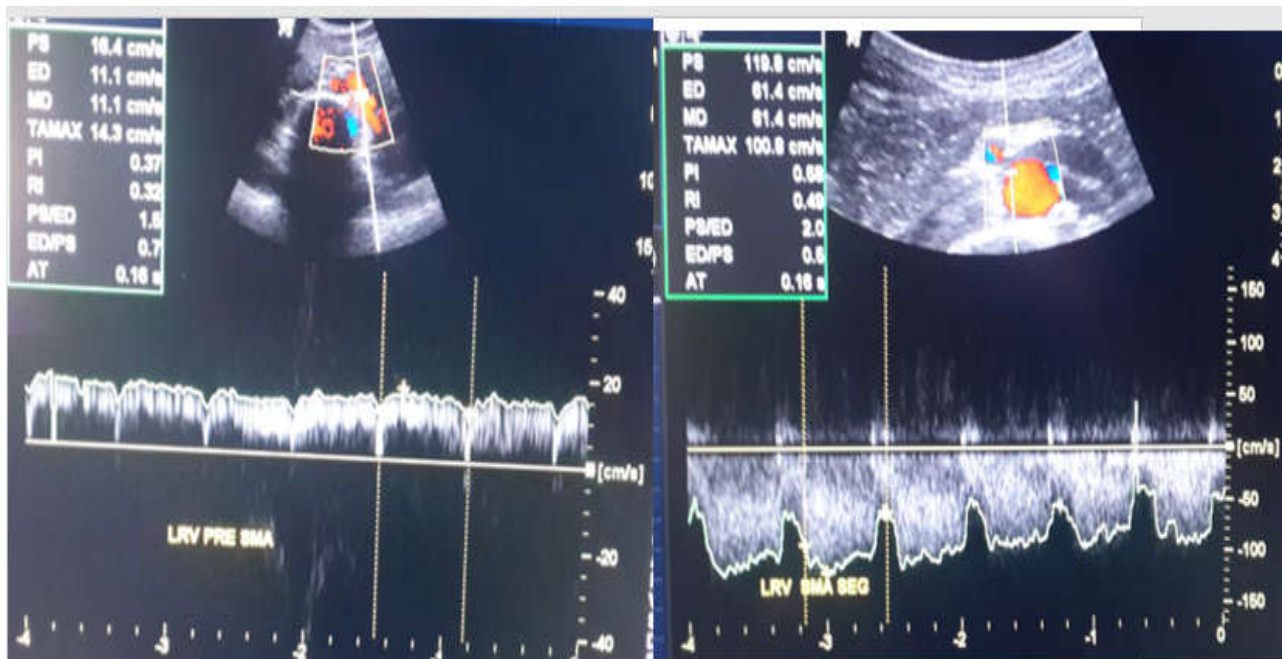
Spectral Doppler of renal vein in pre SMA and SMA segments in a case of nutcracker syndrome
